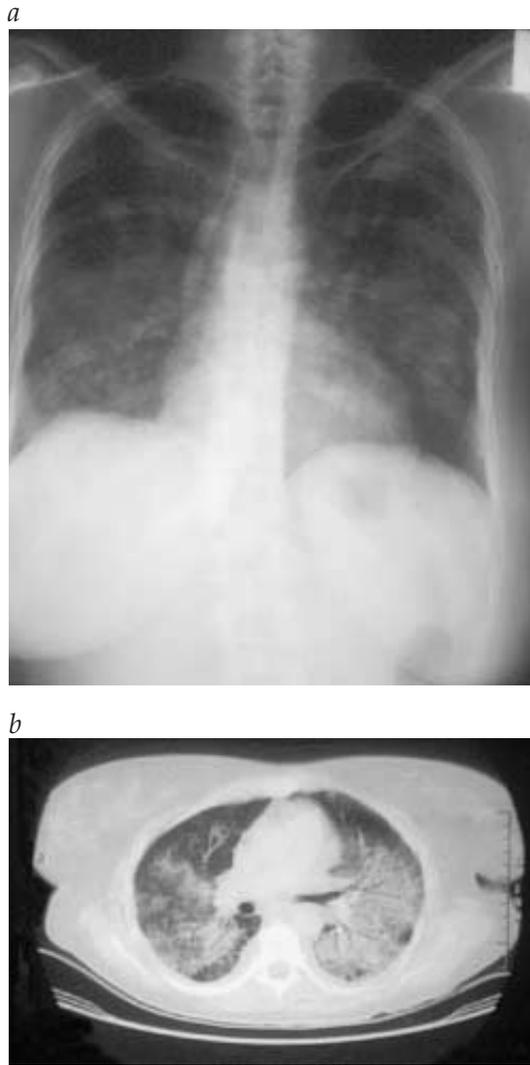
The nodular infiltrates of the lung in Wegener granulomatosis are shown less extensively in a standard radiograph (a) than in a computed tomographic scan (b).
